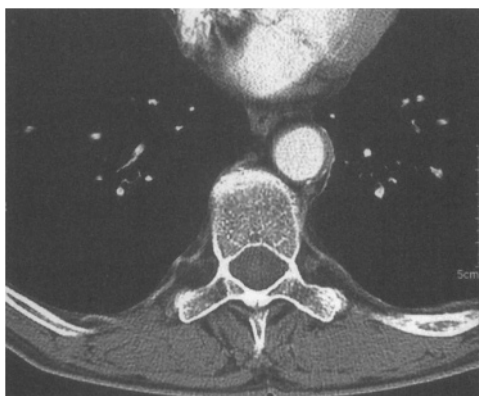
CT scan : intercostal vessels in paraspinal regions of the thorax
